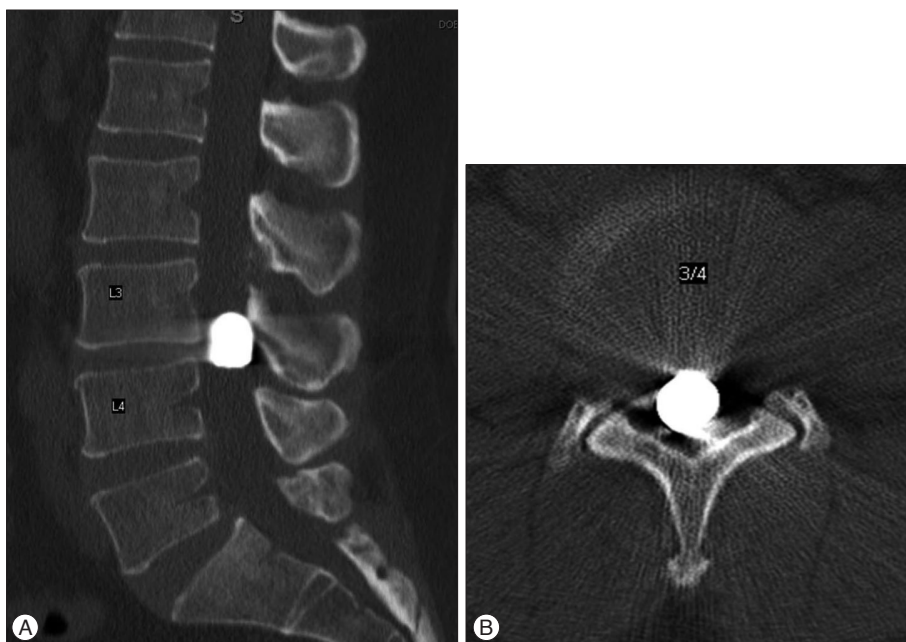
Noncontrast CT reconstructed sagittal (A) and axial (B) images of the lumbar spine. The bullet within the spinal canal was pointed cephalad at the L3-4 interspace.
